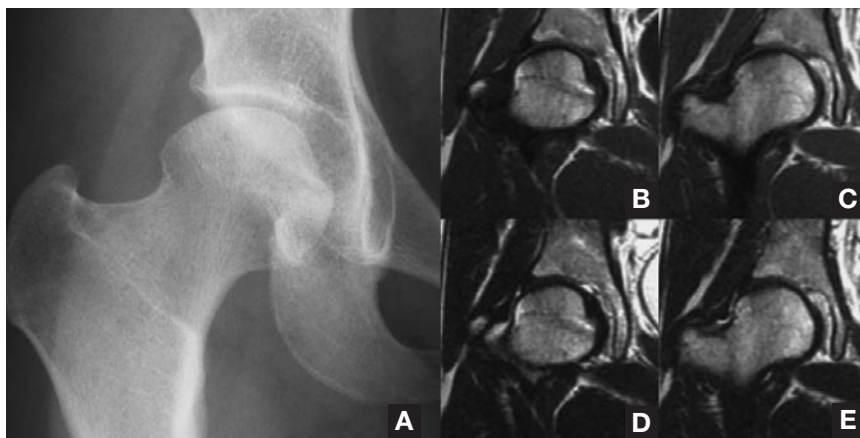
(A) Radiograph at the latest follow-up shows no abnormal findings except mild residual sclerotic lesion of the femoral head. An extremely small low-signal lesion of the upper part of the femoral head was still seen both in T_1 -weighted (B, C) and T_2 -weighted (D, E) magnetic resonance images.
